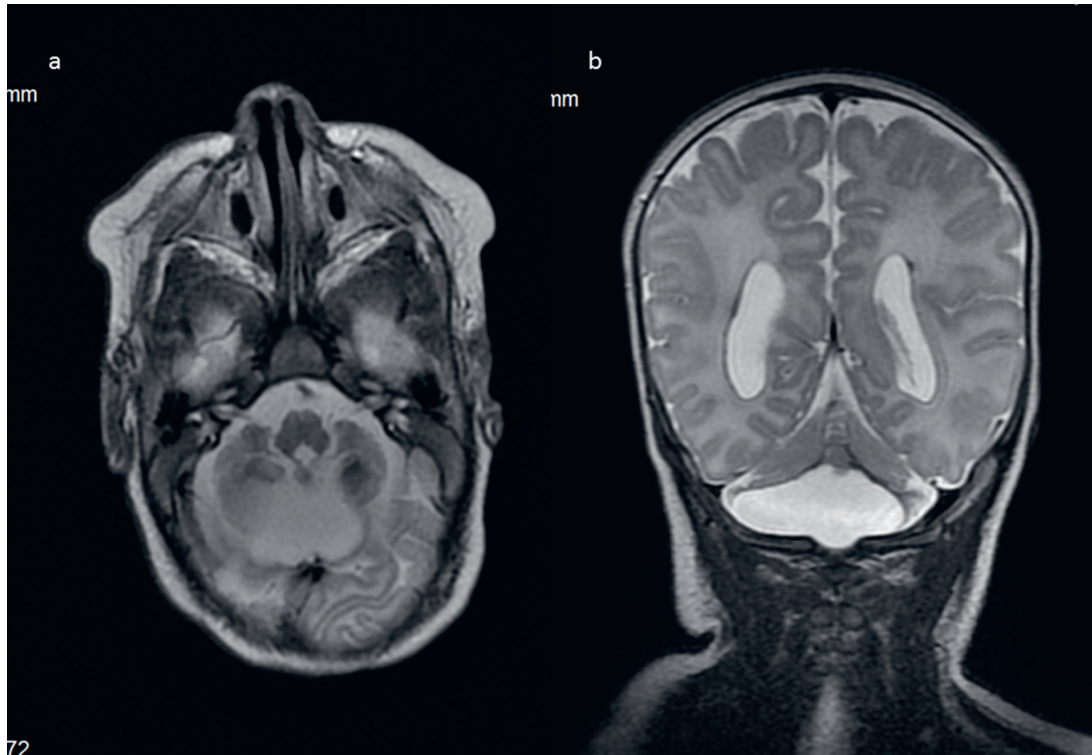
Female second twin born at GA of 25 weeks, examined at 42. FSE/T2-weighted images in axial (a) and coronal projection (b). Posthemorrhagic destruction of both cerebellar hemispheres with hypointense deposits of hemosiderin and hyperintense cystic space between and below the hemispheres
